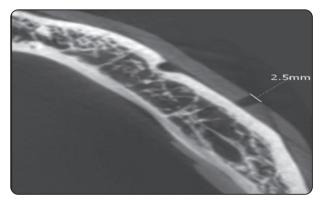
The diameter of soft tissue lesion measured on the CBCT axial cut of one of the mandibular models using EZ3D- I linear measurement tool.
